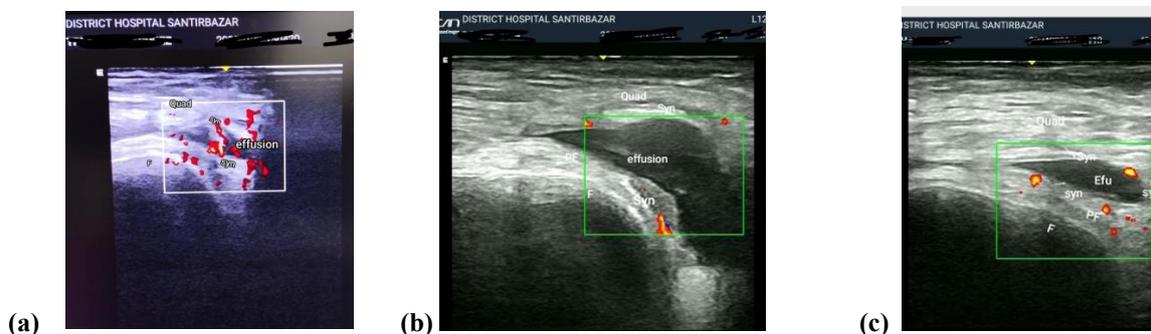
(a), (b), (c): USG of knee as transducer placed transversely through suprapatellar recess. Fluid is seen as an anechoic (black) or hypoechoic area between the quadriceps tendon (superficially) and the prefemoral fat pad/ femur (deeply) and power doppler study as red dots indicating increase vascularity within synovium. Quadriceps (quad), femur (F), prefemoral fat pad (PF), synovium (syn), effusion (efu)
